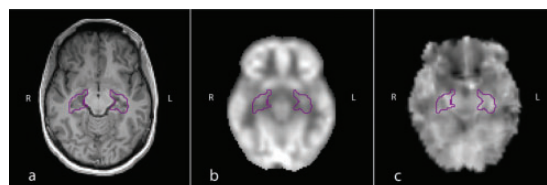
T1-weighted, ASL MRI, and  $^{18}\text{F}$ -FDG - PET images obtained from a patient with right mTLE patient. a) T1-weighted axial images registered in MNI atlas showing overlaid left and right hippocampi for calculation of hypoperfusion and hypometabolism. b) PET-CT axial image registered on MNI atlas showed hypometabolism with  $\text{AI} = -5.79$  for the hippocampus. c) Pulsed ASL axial image registered on MNI atlas represented hypoperfusion for hippocampus with  $\text{AI} = -12.4$ .
